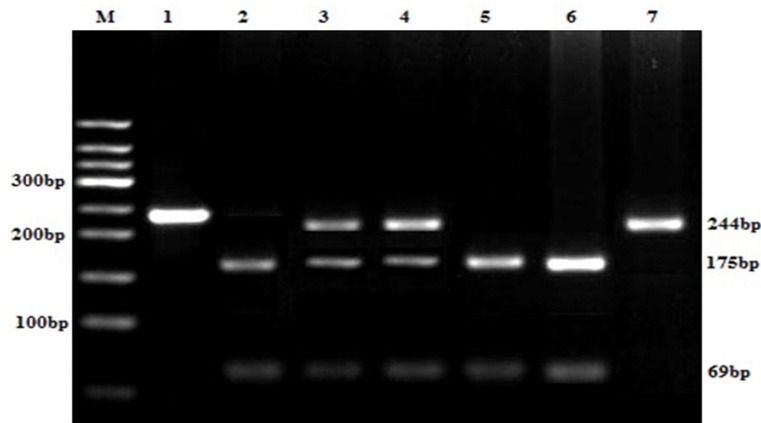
Agarose gel electrophoresis images for *ABCB1* C3435T. 2, 5 and 6 lanes: CC genotype; 1 and 7 lanes: TT genotype; 3 and 4 lanes: CT genotype.
